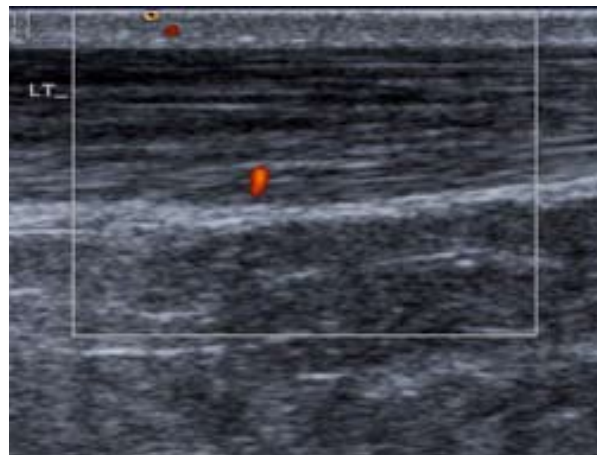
Ultrasound image of thickening of Achilles tendon
